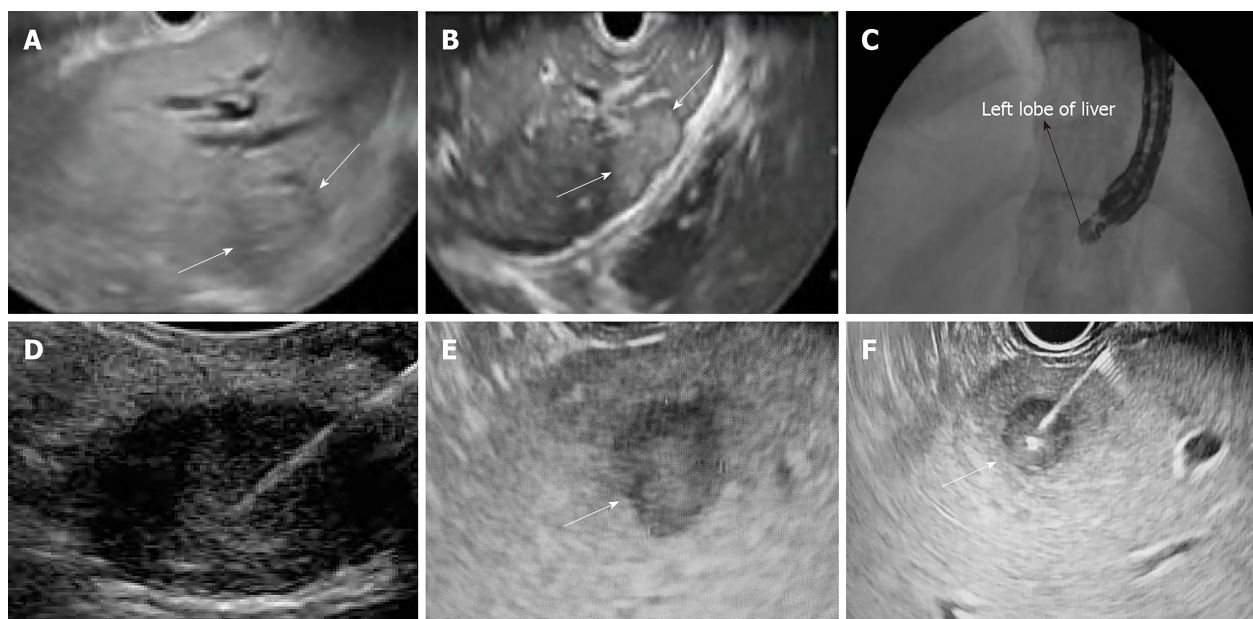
The endoscopic ultrasound guided liver biopsy provides clinicians with a real-time, detailed view of the biopsy needle through the course of the liver.
